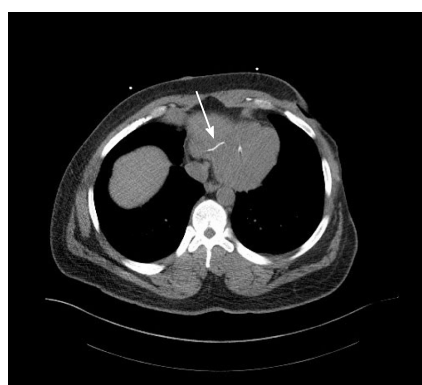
Computed tomography of the chest showing liner foreign body in the right ventricle.
